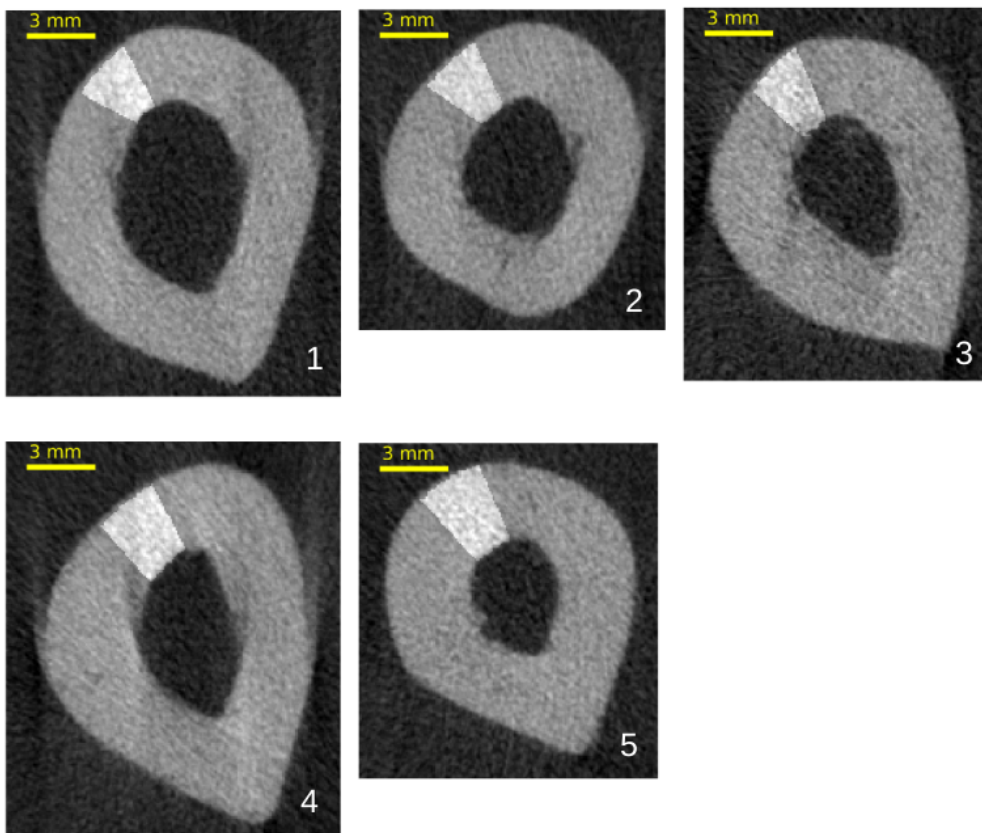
A representative cross-sectional HR-pQCT slice of the radius for each subject. The region of interest corresponding the ultrasound measurement site is highlighted
